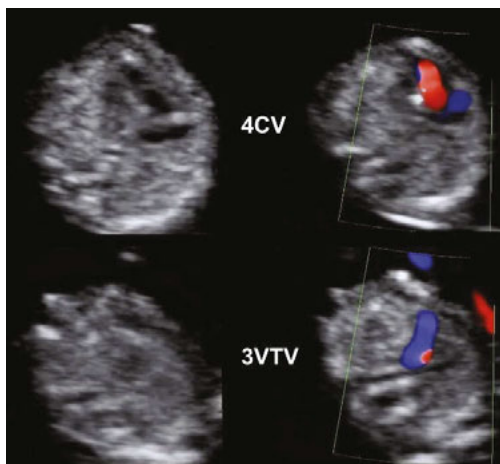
Hypoplastic left heart syndrome (HLHS) seen during EFCS in a B-mode with color Doppler mapping. Abbreviations: 4CV — four-chamber view; 3VTV — three-vessel and trachea view.
